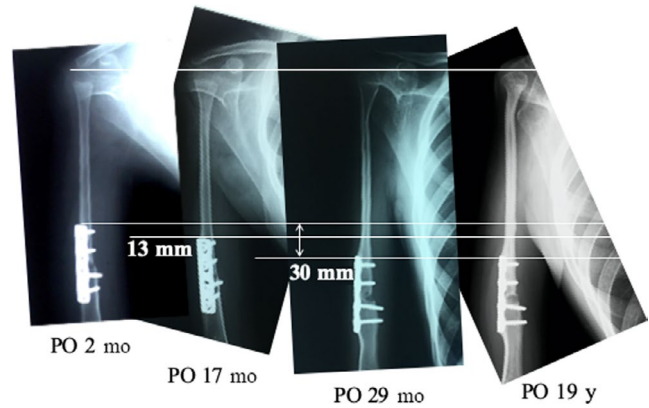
Radiographs showing postoperative longitudinal growth of transferred fibula in case one
